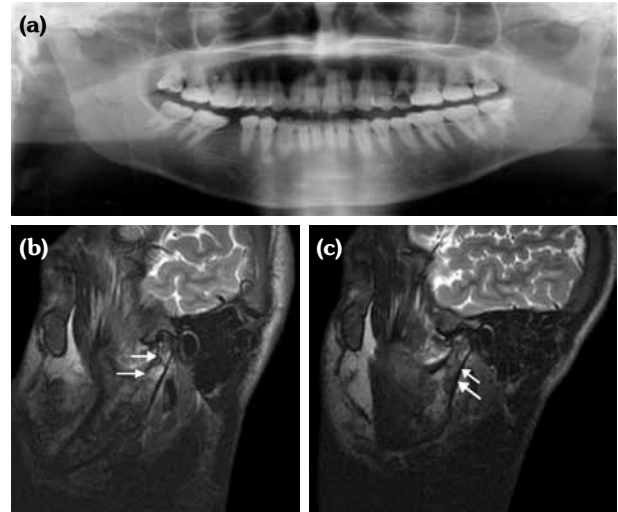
Panoramic radiograph imaging (a), magnetic resonance imaging of left temporomandibular joint showing a signal change at condylar head and neck of bilateral jaw, suggesting bone edema with T₂ hypersensitivity (b) magnetic resonance imaging of right temporomandibular joint showing bilateral ramus infarction as a hypointense signal in T₂ (c), (arrows).
